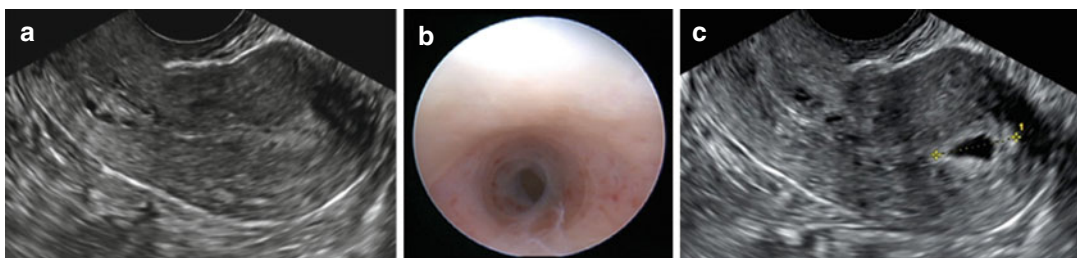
“One stop uterine diagnosis”. (a) 2D ultrasound; (b) Hysteroscopy with the Trophy hysteroscope; (c) Contrast sonography showing cavity of less than 2 cm in sagittal plane
